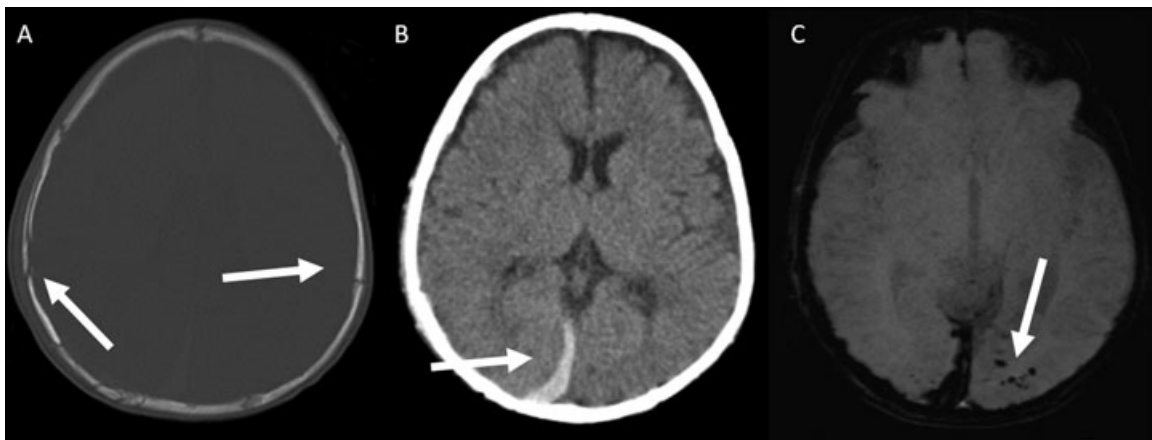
Axial CT images (A, B) and axial SWI MR image (C) of a child with confirmed nonaccidental TBI. Multiple bilateral linear fractures (arrows) (A) are seen as well as an acute, hyperdense subdural hematoma along the falx (arrow) (B). SWI image (C) reveals additional petechial intraparenchymal hemorrhagic shear lesions within the left occipital lobe (arrow).
